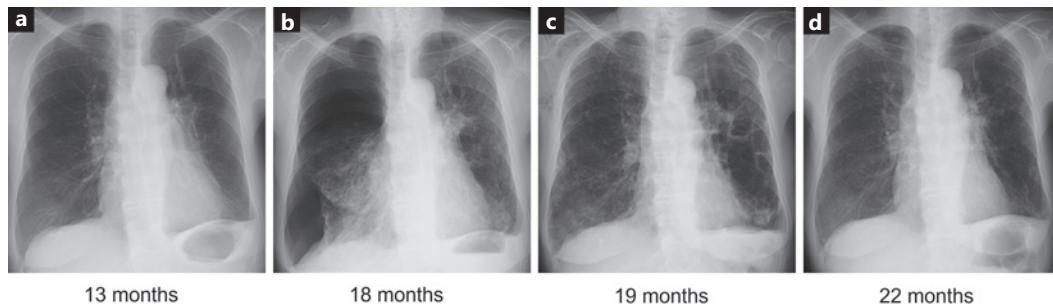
Chest X-ray during chemotherapy chest X-ray showing the lungs at the initiation of osimertinib therapy at 13 months (a), appearance of pneumothorax at 18 months (b), enlargement of the cysts with osimertinib withdrawal at 19 months (c), and disappearance of the cysts after four cycles of second-line therapy at 22 months (d).
